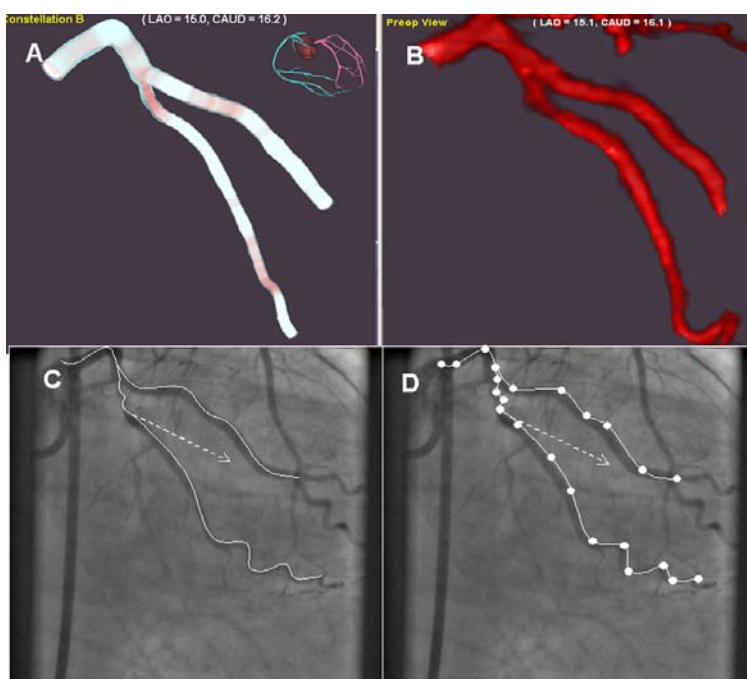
Three-dimensional representation of the coronary artery. (A) A three-dimensional reconstruction of the artery using the CardiOp®-B software. (B) The same arteries extracted from a multislice CT data set (C and D), displayed as navigational centerlines with a directional vector on the live fluoroscopic images.
